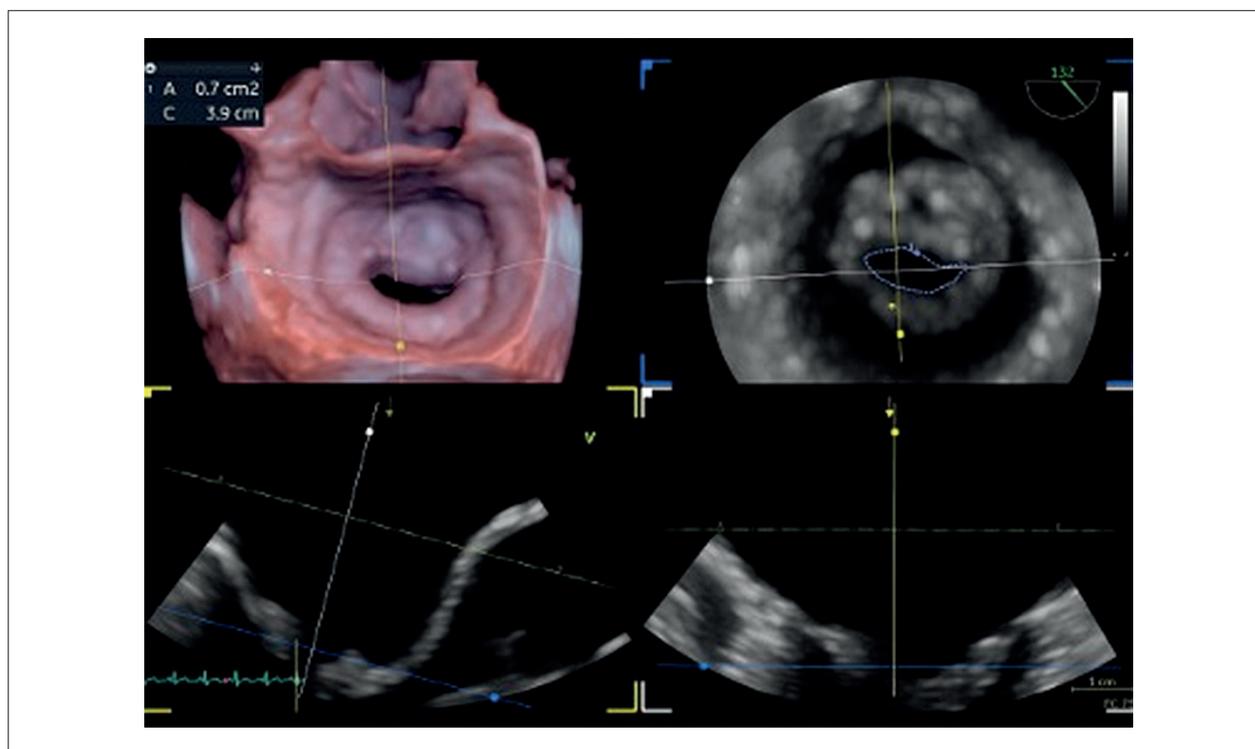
Multiplanar reconstruction by three-dimensional transesophageal echocardiography in mitral stenosis, allowing precise positioning of the plane in the narrowest portion of the valve orifice during diastole, facilitating reliable anatomical measurement of the functional area.
